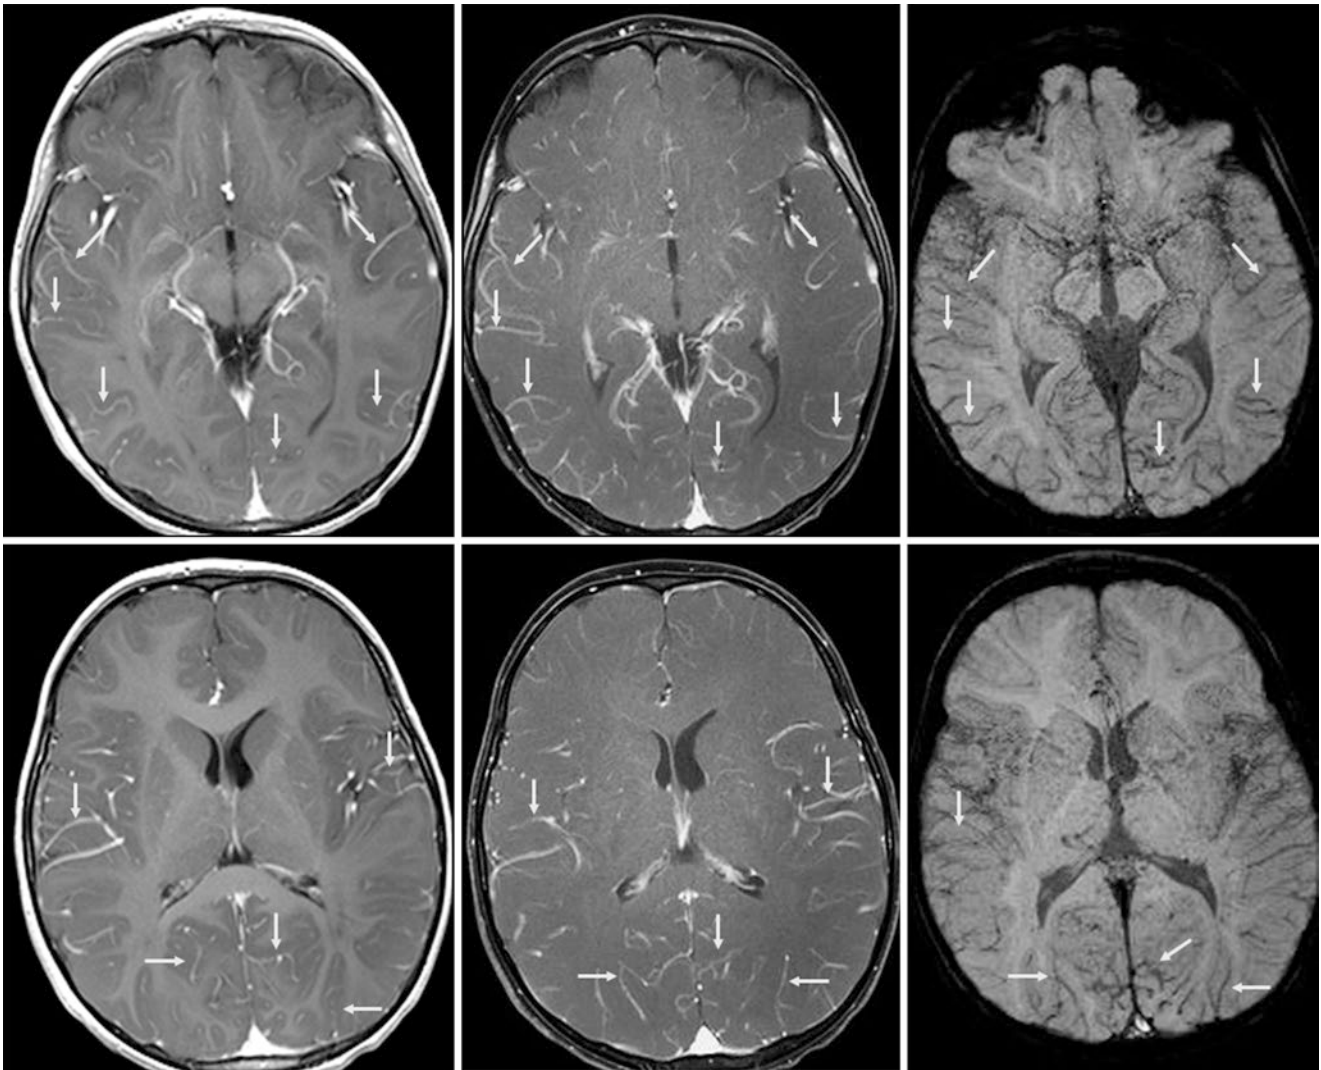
A 2 year old with esotropia (nonacute) had a negative 3T MRI with IV sedation that showed mild pseudo-LMCE (arrows) on postcontrast GET1WIs (left column), which was a bit more pronounced on fat-suppressed SE T1WIs (middle column). On SWI (right column), the visibility of the venous vasculature is probably attributable to deoxyhemoglobin
